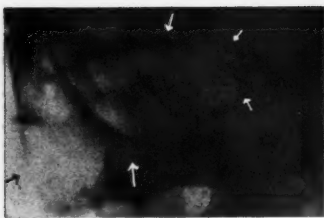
Roentgenogram of the temporal bone after the Stenvers method. Total destruction of the pars mastoidea and of the pyramid by cholesteatoma. There remain only rather sharply demarcated vestiges of the cortical layer of both.
